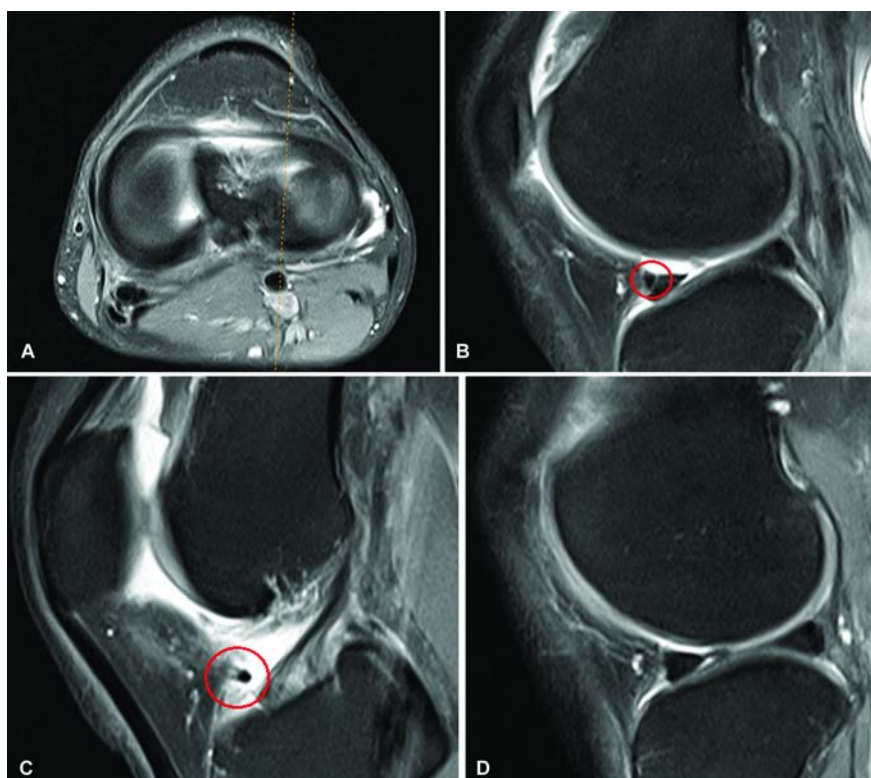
MRI scans of the left knee in a 25-year-old patient M. showing: A – tight meniscomeniscal ligament in transverse view; B, C, D, – sagittal view (B – meniscomeniscal ligament portion attached to the lateral meniscus being susceptible of a tear; C – cross section of the ligament in the central meniscal aspects; D – distinct contour of the anterior horn of the lateral meniscus)
